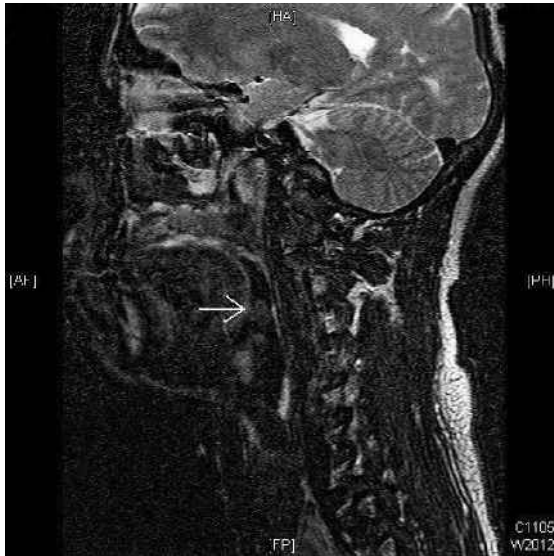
Sagittal T2-W MR image of the neck shows the mushroom-shaped tumour (arrow) on the base of the tongue.
